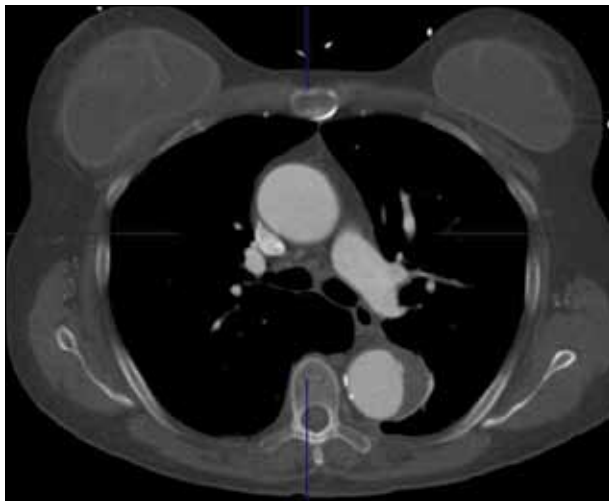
Axial CT scan showing the intramural hematoma.
